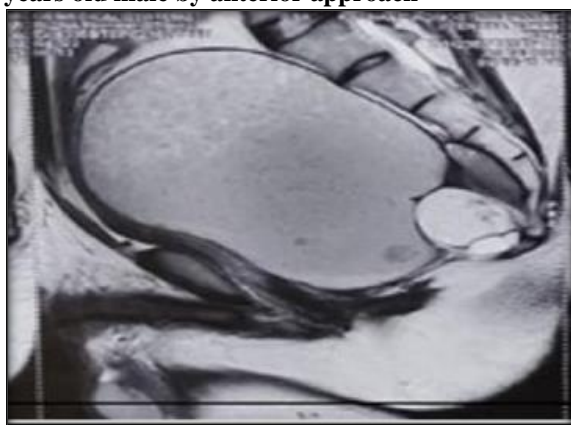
MRI SHOWS WELL DEFINED LARGE LOCULATED SEPTATED CYSTIC LESION IN LOWER PRESACRAL REGION. IT IS SEEN AS HETEROGENOUS HYPERINTENSE ON T2 WT IMAGE (AS SHOWN IN BELOW FIGURE) AND HYPOINTENSE ON T1WT IMAGE. AREAS OF FATTY COMPONENTS AND TINY CALCIFIATIONS NOTED WITHIN. A LESION WAS ABUTTING THE LOWER PART OF SACRUM(S3-S5) AND COCCYX.
